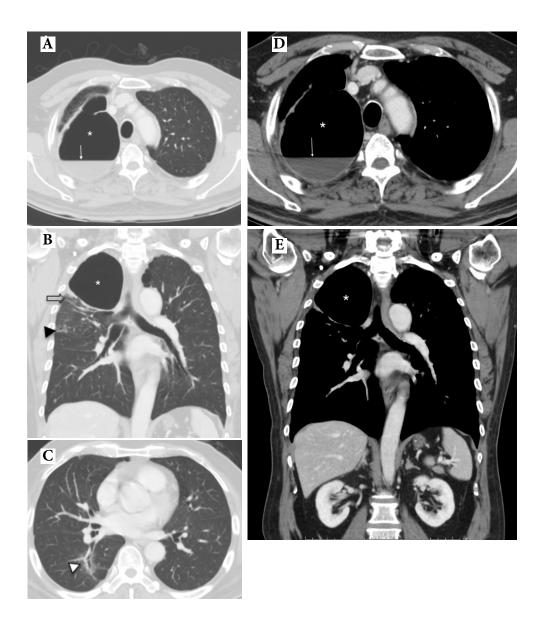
The contrast enhanced CT of the chest for full evaluation of infected lung bulla in axial (A,C,D) and coronal views (B,E) of the lung window (A,B,C) and the mediastinal window (D,E) eight days after the treatment shows a thin-walled cavitary lesion at the apical segment of the RUL (asterisks) with a smooth internal margin and an internal air-fluid level (arrows in A,D), corresponding with the air-fluid level in the bulla on figure 4B. A small area of the centrilobular nodules in RUL (black arrow head in B) corresponding with the patchy opacity in figure 5B and 5C, and minimal residual reticulonodular infiltration at the posterior segment of RUL (open arrow in B), and minimal cylindrical bronchiectasis with ground-glass opacity at the superior segment of RLL (white arrow head in C) confirmed the resolving pneumonia.
